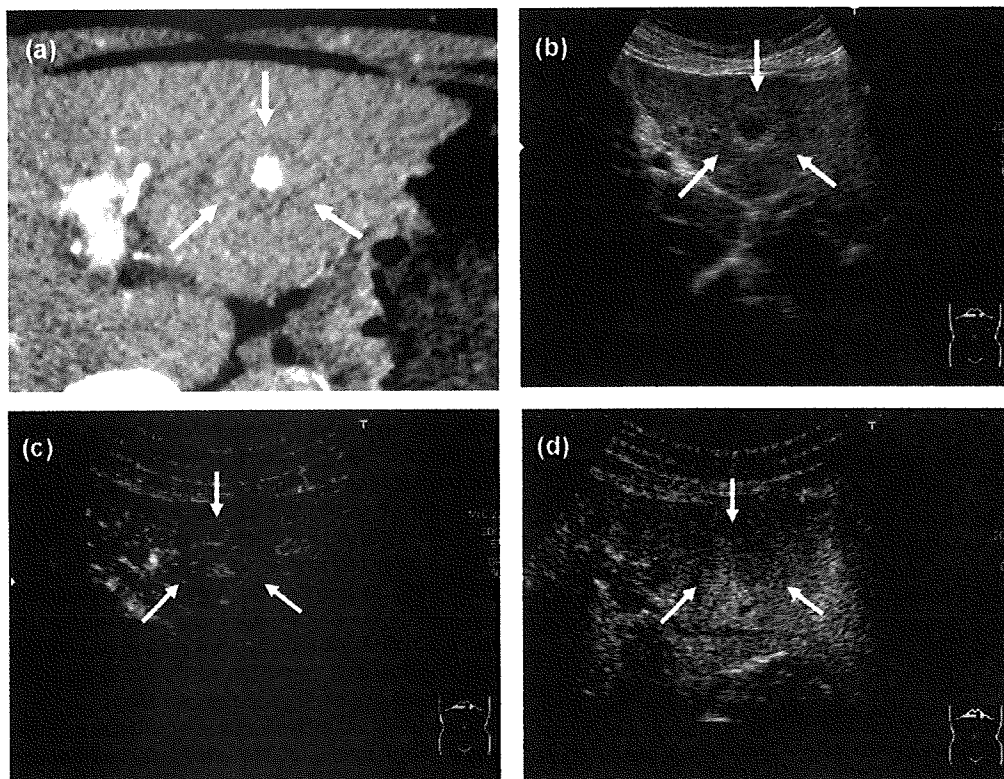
A 74-year-old female, hepatitis C virus-related cirrhosis, HCC with nodule-in-nodule appearance (S3, 28.5 mm; case 9). (a) Contrast-enhanced CT, artery-dominant phase. HCC with isovascular outer nodule and hypervascular inner nodule (arrows). (b) Grey-scale US. HCC with hyperechoic outer nodule and hypoechoic inner nodule (arrows). (c) Contrast-enhanced US, vascular phase. HCC with iso-enhanced outer nodule and hyper-enhanced inner nodule (arrows). (d) Contrast-enhanced US, late phase. HCC with iso-enhanced outer and inner nodules (arrows).
